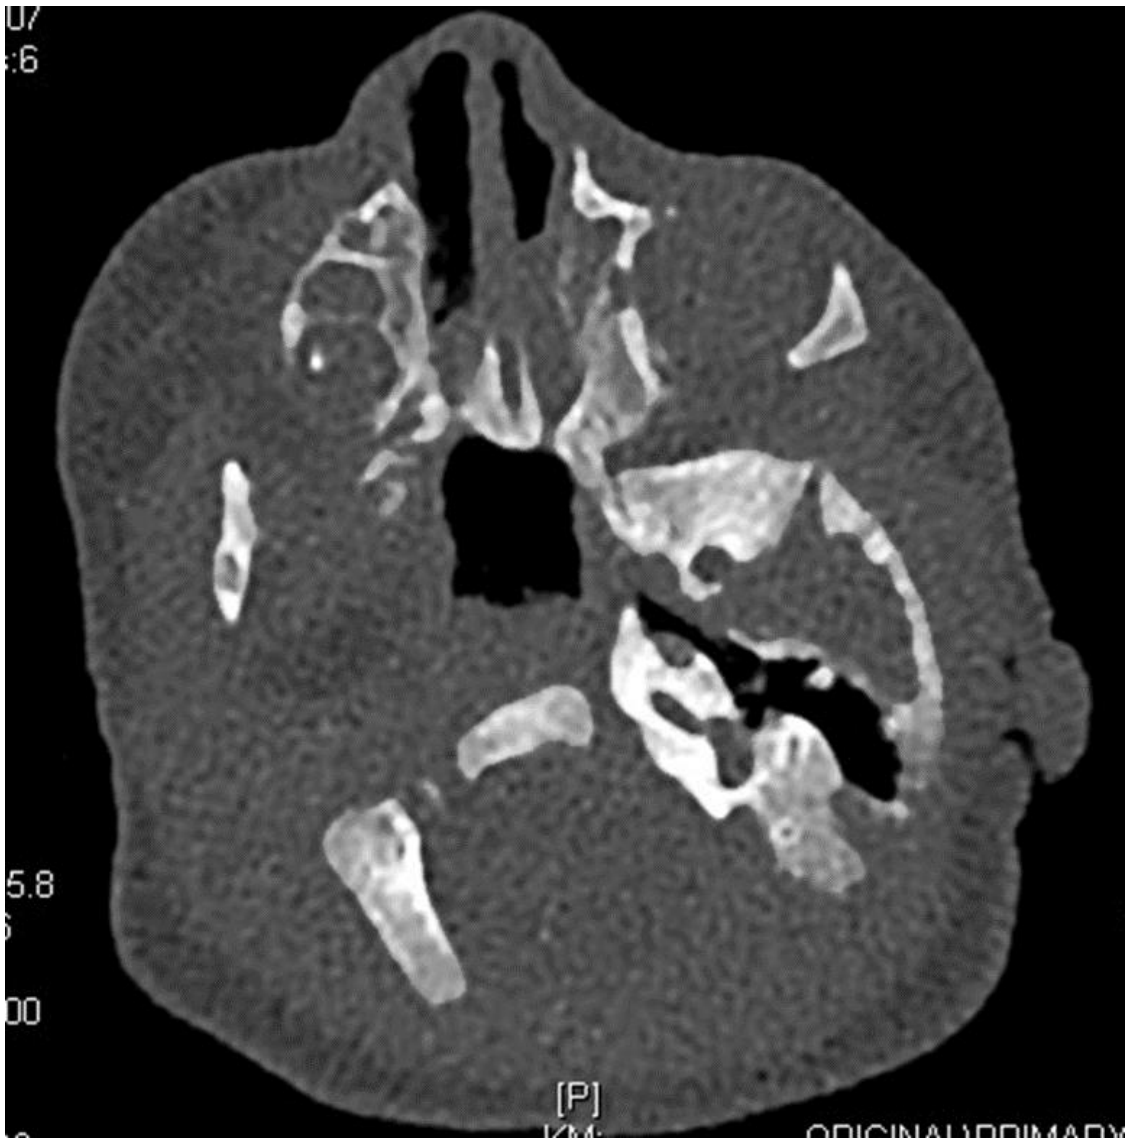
CT-scan: Computerized tomography image in axial plane with bone window of a patient presenting with a bilateral mixed choanal atresia.
